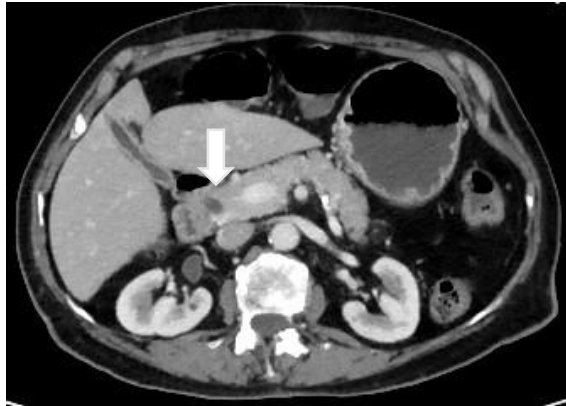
CT enteroclysis (A) axial slice.
